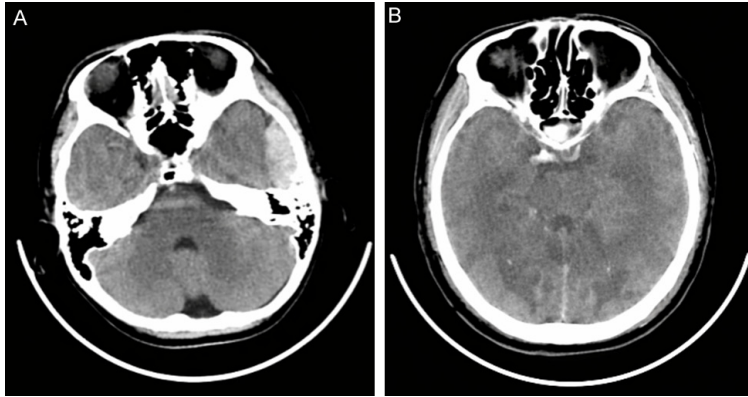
Brain CT scans in patients with intracranial injury. A: Patients with epidural hematoma. B: Patients with combined subdural and intracerebral hematoma.
